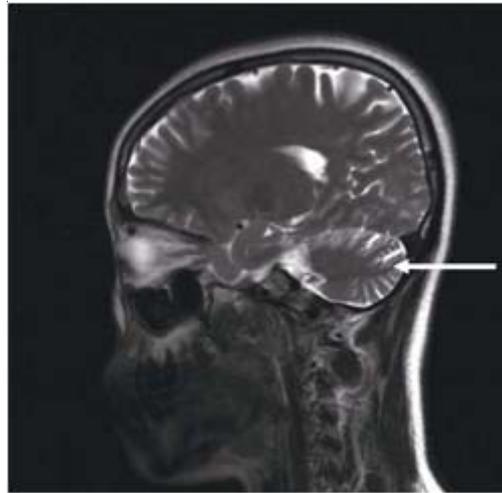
A representative magnetic resonance imaging (MRI) image of patient No. 4 showing obviously widened and deepened cerebellar sulci, suggesting the presence of cerebellar atrophy, as indicated by the white arrow. Major clinical manifestations of the 29-year-old female patient are presented in Table 1.
